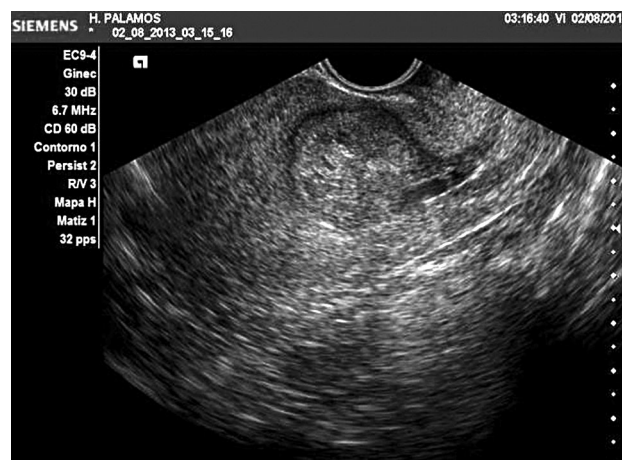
Ultrasound findings suggestive of cesarean scar pregnancy.
